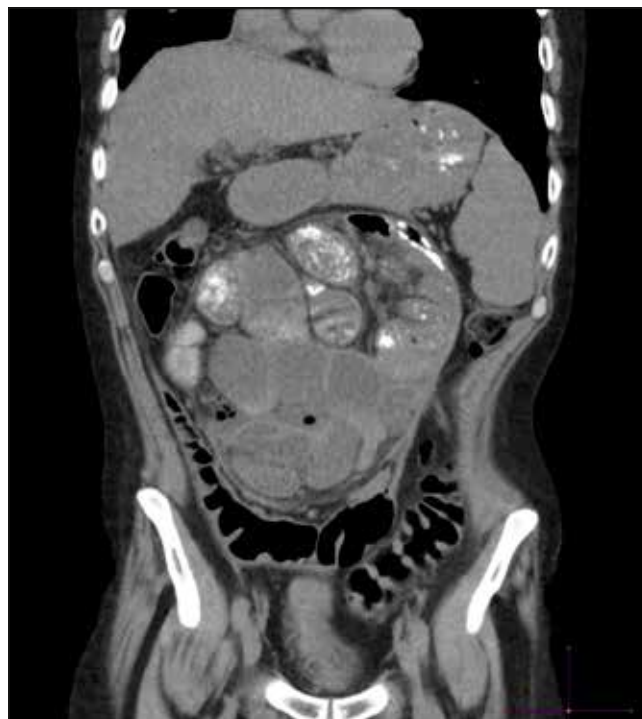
Coronal reformatted image from a CT scan of abdomen demonstrating dilated small bowel loops surrounded by a thin membrane in the central abdomen in keeping with encapsulating peritoneal sclerosis.
